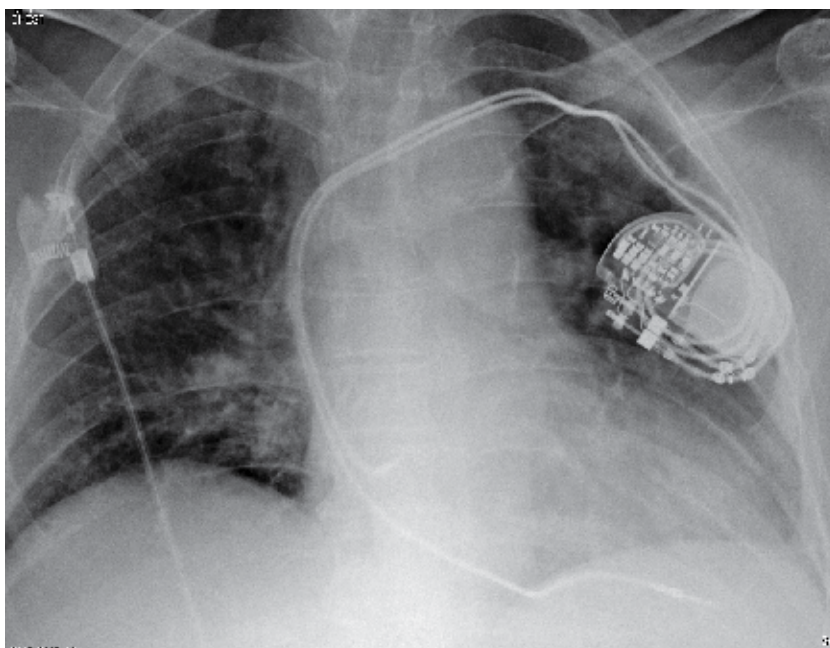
Chest X-ray showing atrial and ventricular leads, with the ventricular lead clearly beyond the cardiac shadow
